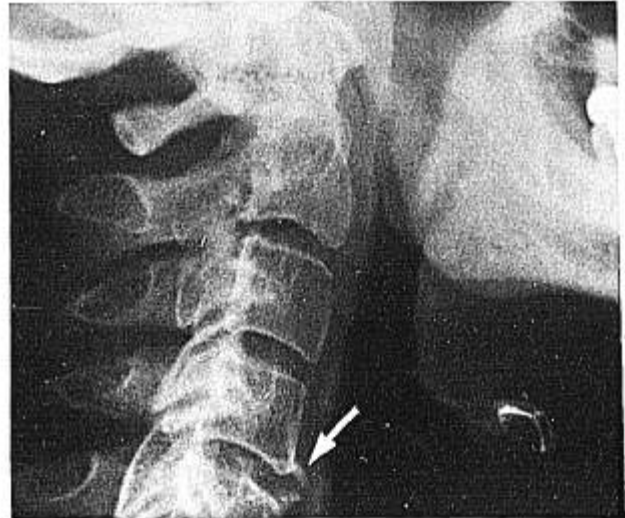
Lateral x-ray of an OSA patient which shows alterations of the cervical vertebrae. The arrow points to the extra bony bridges on the anterior border of the C4 vertebra. Another bridge is seen on the superior part of the C5 vertebra.
